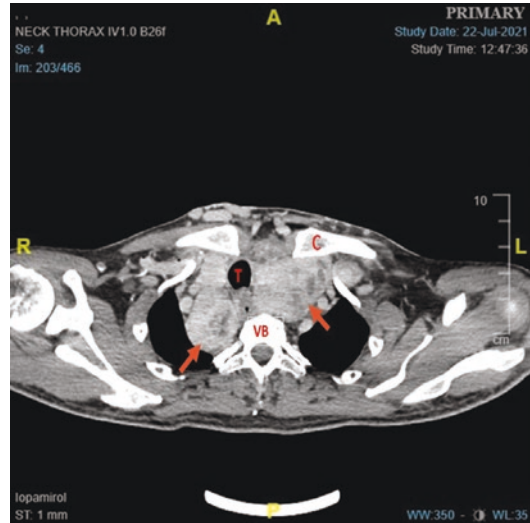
A CT scan image of a retrosternal thyroid mass (arrows), which extends well below the clavicle (C). The trachea (T) is patent as evident by its circular ring
